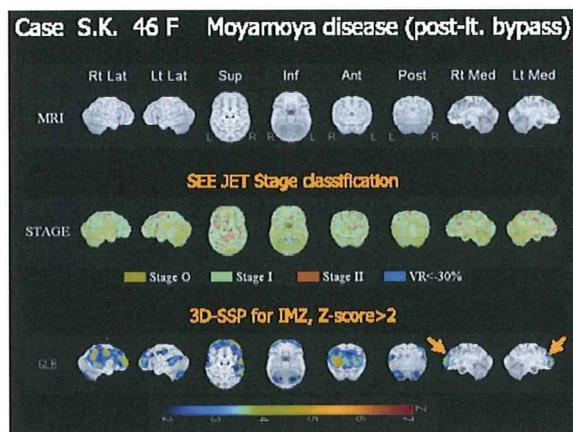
もやもや病の高次脳機能障害例のSPECT画像解析
